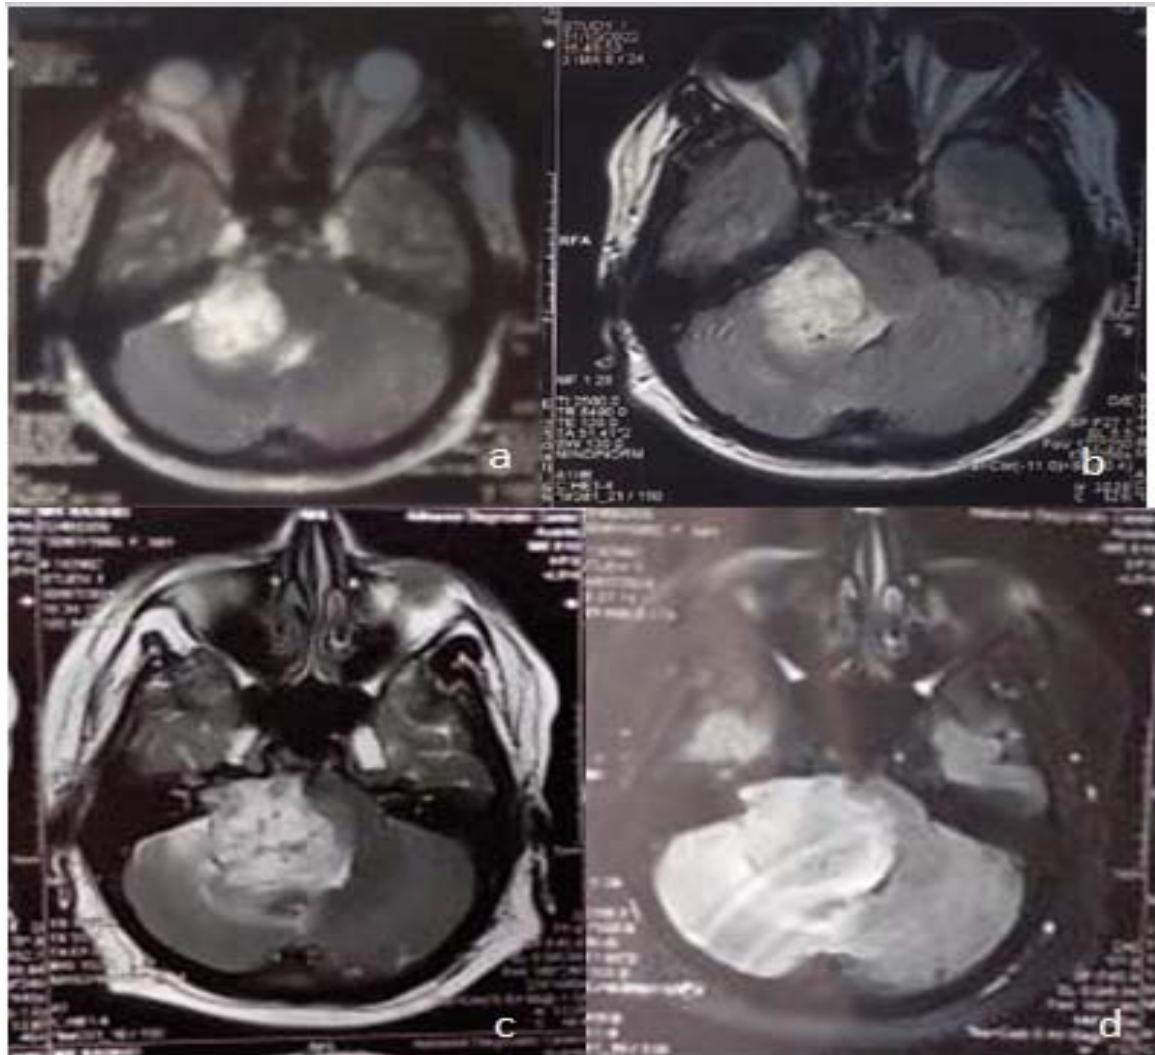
a and b show T2 and FLAIR axial images before SRS respectively of a young male with right CP Vestibular Schwannoma. C and d show T2 and FLAIR axial images 2 years after SRS, with worsening of symptoms and increased oedema as shown in images, based on which he underwent surgical resection.
